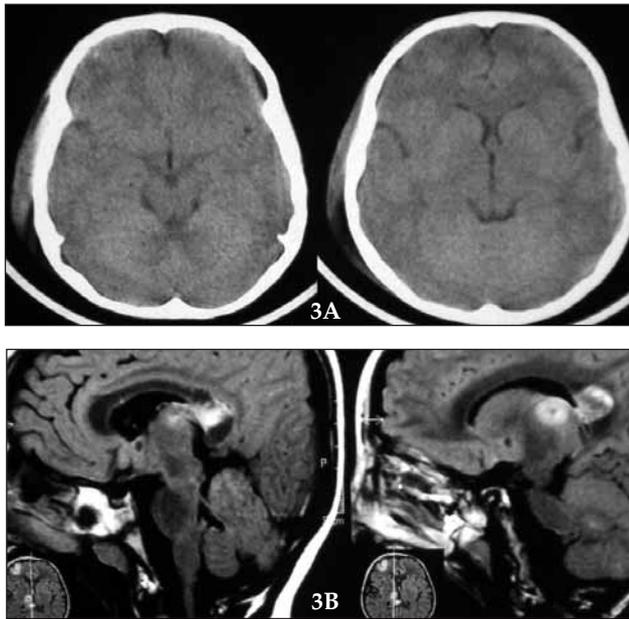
(A) Slices of computed tomography show a normal appearance of brain parenchyma with right side subgaleal traumatic edema. (B) T1 slices of MRI show severe frontal contusion with midbrain and brainstem punctate lesions.
